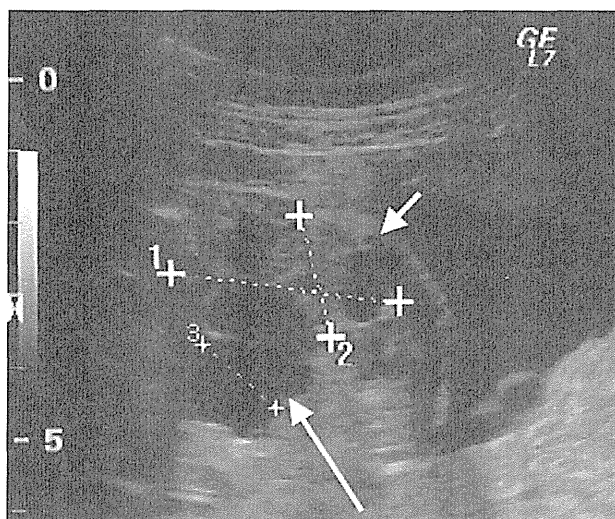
Ultrasound at 31 weeks of gestation revealed a left hydroneurter (long arrow) and a multicystic, dysplastic kidney (short arrow) in fetus A.
